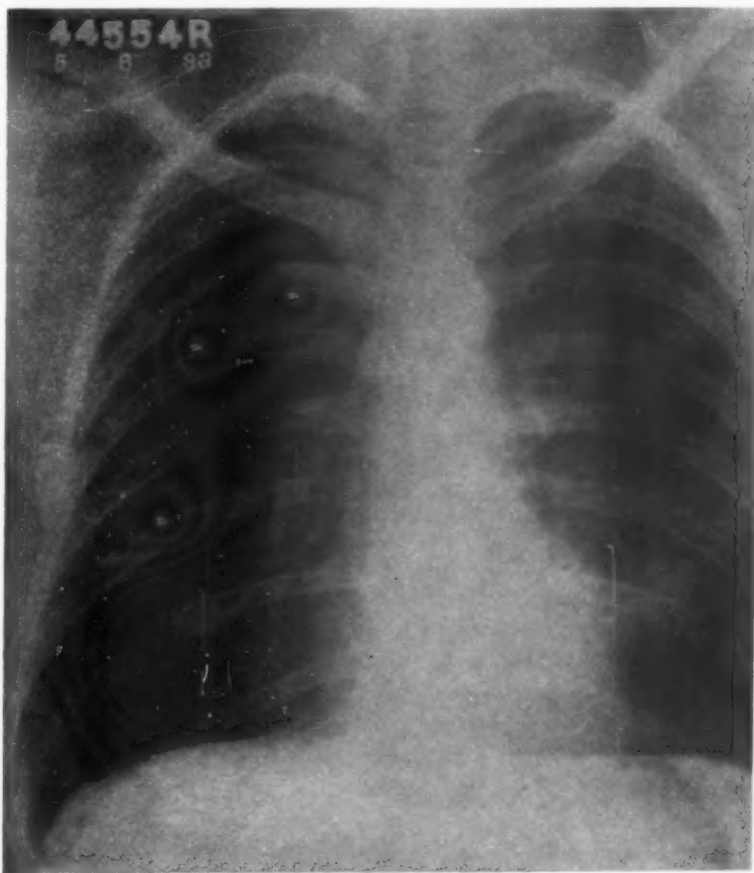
Normal roentgenogram obtained eight months after onset of illness.
